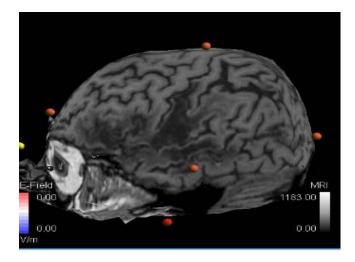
Participant #3 (S.H.) MRI. Findings of the current MRI showed an extensive area of brain parenchymal loss associated with perifocal gliosis, involving the left parietal lobe extending inferiorly to the anterior left temporal lobe and also posteriorly to the left occipital lobe. The above caused significant ex vacuo dilatation of the left lateral ventricle. Prominence of the third ventricle was also noted. In addition, subtle hypointensity involving the left corticospinal tract, causing asymmetry of the cerebral peduncles and pons was noted, compatible with a left-sided Wallerian degeneration.
